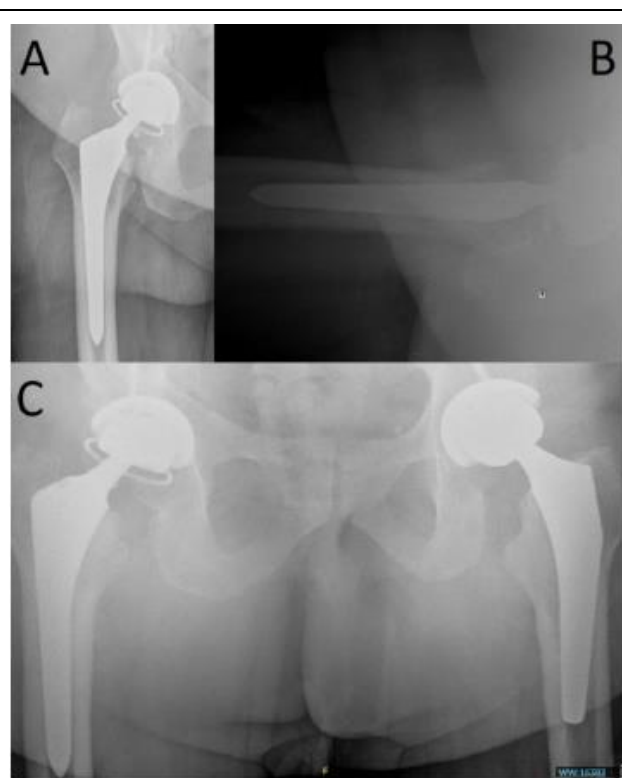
5A-5C Radiographs (Case 2). Postoperative anteroposterior right hip (A), lateral right hip (B), and anteroposterior pelvic (C) radiographs following right hip revision arthroplasty.
